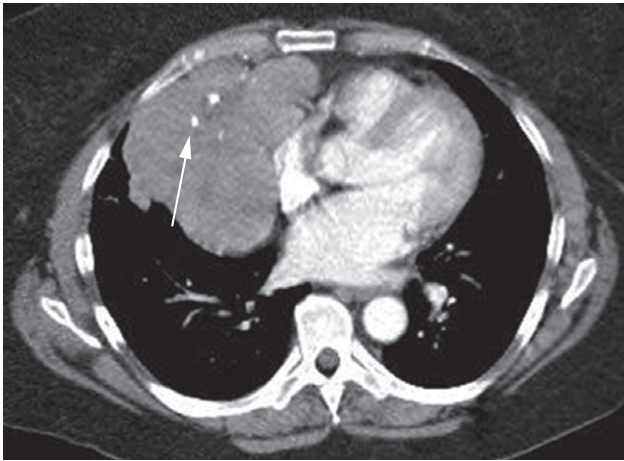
Thymoma. CT showing a large, lobulated, anterior mediastinal mass with punctuate calcification (arrow), which proved on resection to be a thymic tumour.
